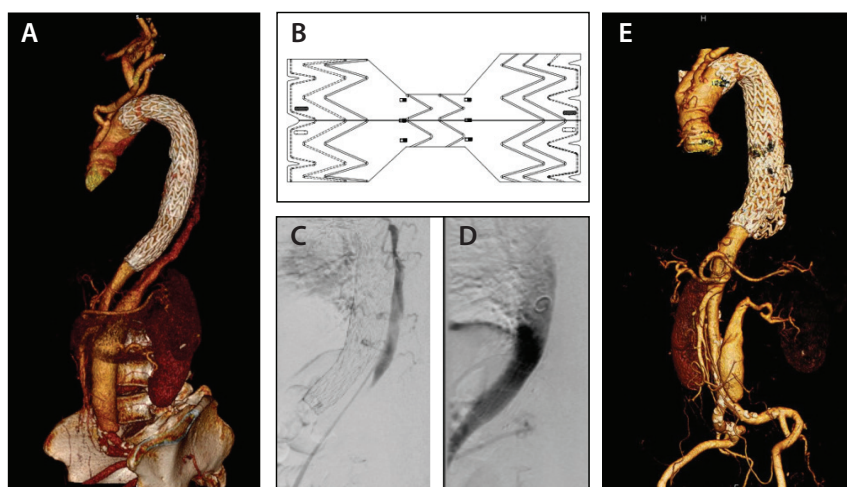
Preoperative CTA (A). Design of the custom-made candy plug Relay device (B). Intraoperative image showing type Ib endoleak to the false lumen (C). Intraoperative image showing complete exclusion after implant of the candy plug Relay device (D). CT at 1 year showed no false lumen perfusion (E).
